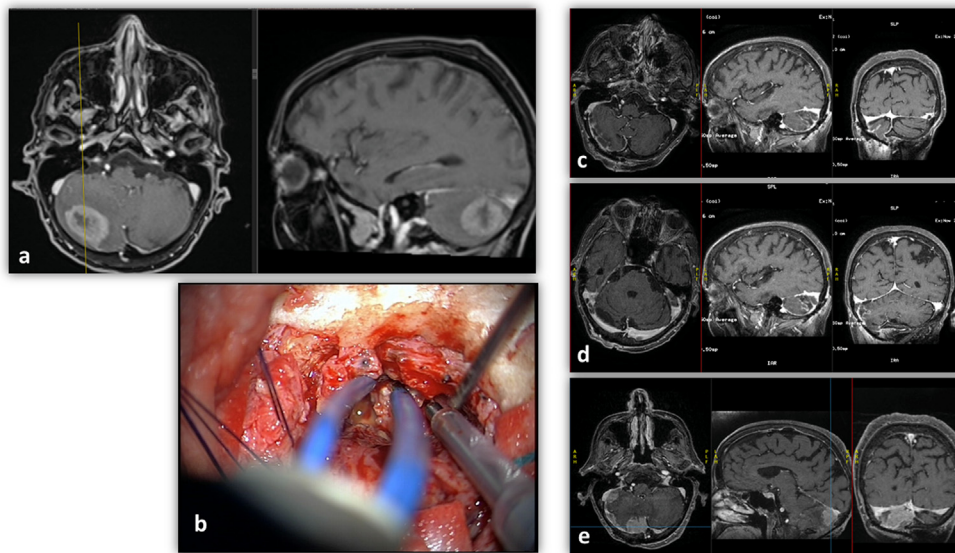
a: axial and sagittal T1 weighted MR images with Gadolinium of a hemispheric right cerebellar metastasis in an 82-year-old female affected by breast cancer (RPA Class III, GPA score 2). b: intraoperative image during tumor removal. c: post-operative T1 weighted MR images with Gadolinium, demonstrating complete removal of the lesion. d: post-operative T1 weighted MR images at seven months after surgery showing a significant recurrent lesion with involvement of the cerebellar-pontine angle. The patient died 8 months after surgery due to local disease progression.
